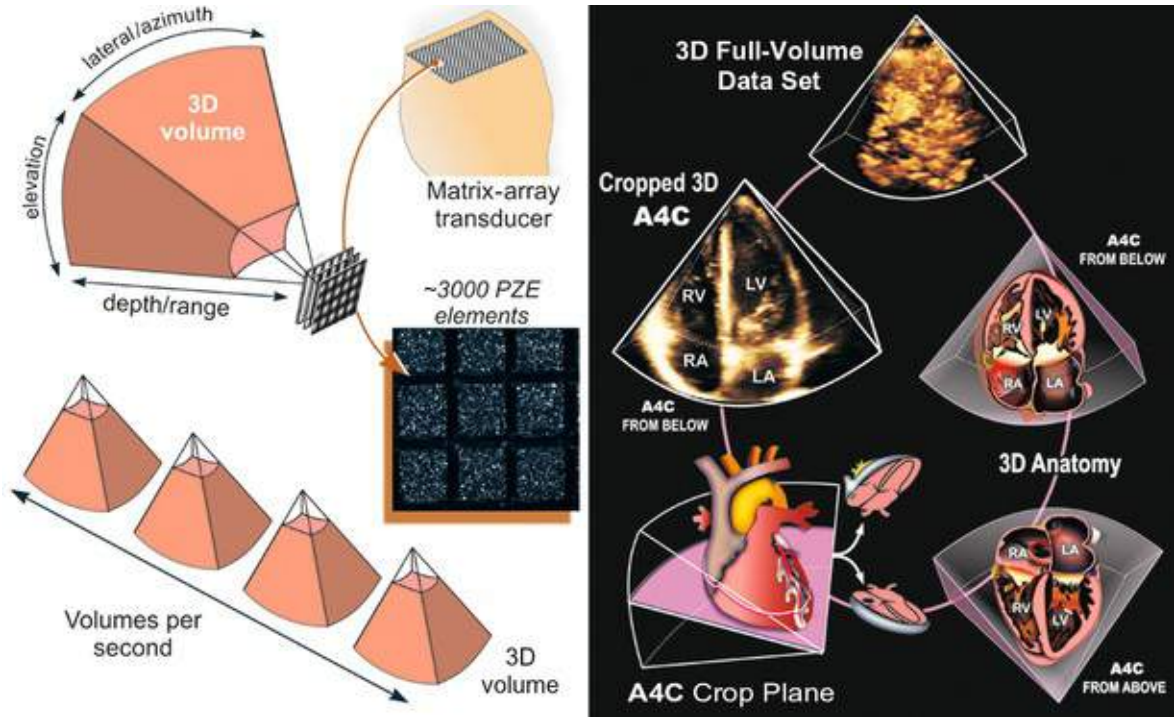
Three-dimensional echocardiography using a matrix-array transducer. A waffle-like matrix array (left panel) is used to obtain pyramidal “volumes” for real-time 3D data sets that can be cropped (right panel) and rendered in three dimensions. Alternatively, two-dimensional planes can be “cut” through any part of the 3D data set. A4C, Apical four-chamber view. (Modified from Bulwer BE, Rivero JM, editors. Echocardiography Pocket Guide: The Transthoracic Examination. Burlington, Mass: Jones & Bartlett Learning, 2011, 2013, p 208. Reprinted with permission.)
